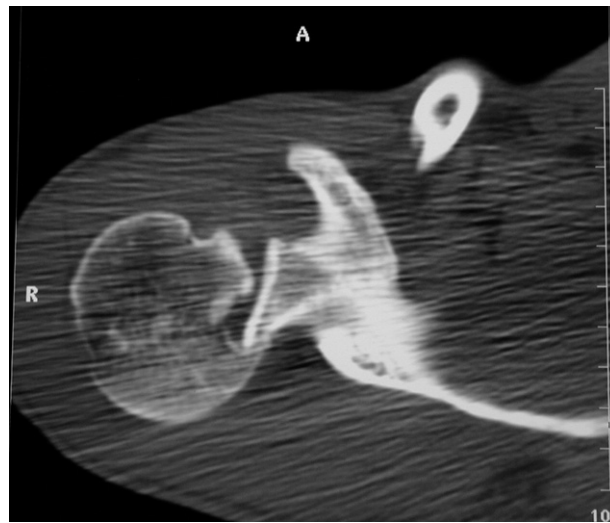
Axial computed tomography scan of the right shoulder shows impaction fracture with approximately 20% involvement of the anterior humeral head.
